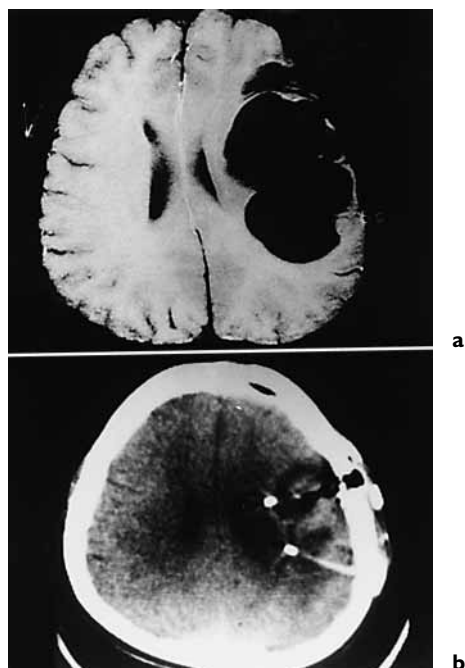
a MRI showed an enlarged huge cyst. b Two Ommaya reservoirs inserted in the cyst.
